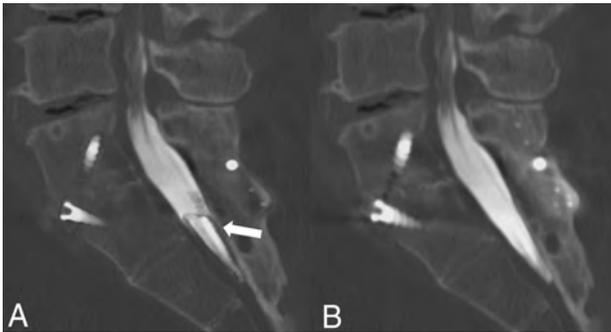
A, Sagittal MAR CT image with fusion hardware in the lumbar and sacral spine demonstrates apparent hypodense material (*white arrow*) in the dorsal spinal canal not seen in the non-MAR image. This filling defect could be mistaken for arachnoiditis, tumor, or layering debris and lead to unnecessary further work-up. B, Non-MAR image without evidence of material within the spinal canal.
